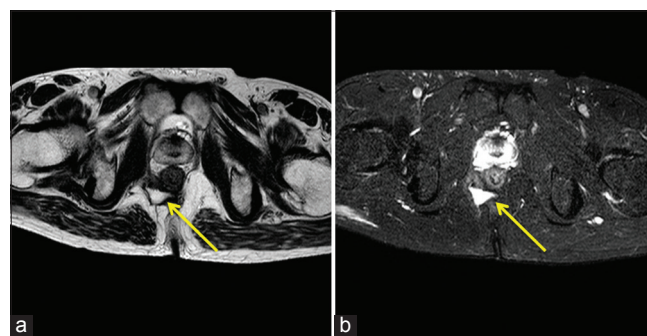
(a and b) Axial T2-weighted and axial proton density images shows a hyperintense fluid collection in right ischiorectal fossa communicating with a trans-sphincteric hyperintense fistulous tract (yellow arrow)
